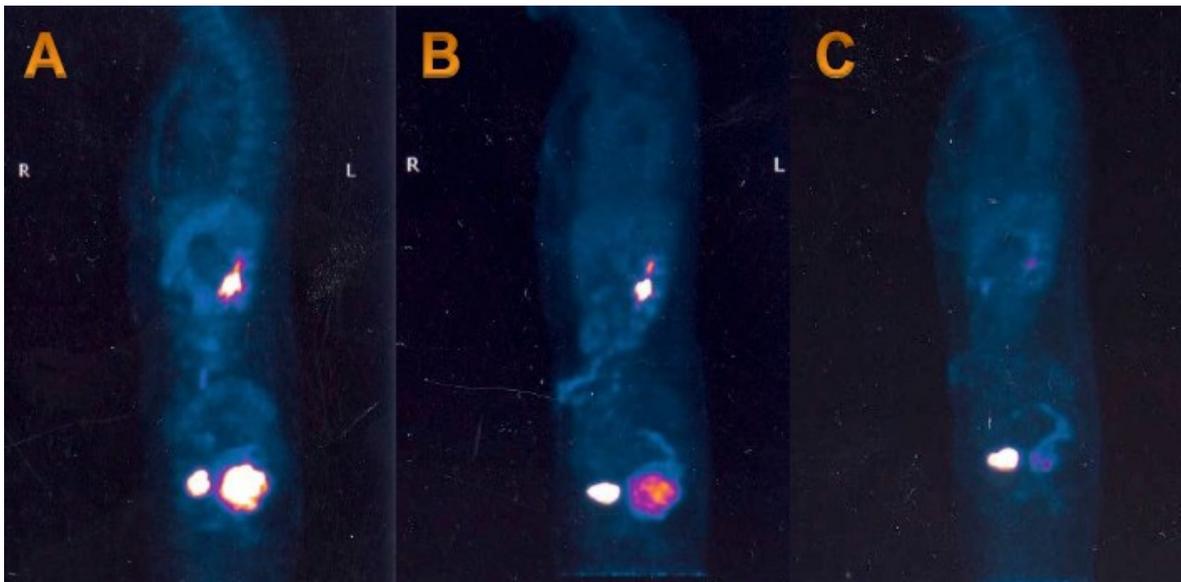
A) 18F-FDG PET-CT at diagnosis (baseline); B) after 4 months of oral imatinib therapy; C) after radiotherapy concomitant to imatinib. PET also shows response to neoadjuvant imatinib and radiotherapy.
